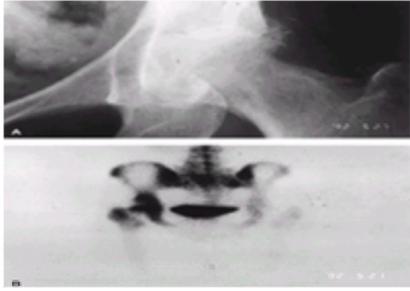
Septic arthritis. A: The radiograph shows complete loss of the joint space and some irregularity of the femoral head. B: The bone scan (posteroanterior view) shows markedly increased uptake of technetium on both sides of the joint.
